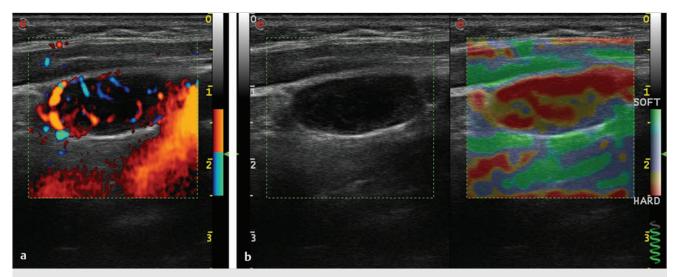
Metastatic lymph node. (a) Power Doppler evaluation. (b) Strain elastography evaluation. The node appears mostly hard.
